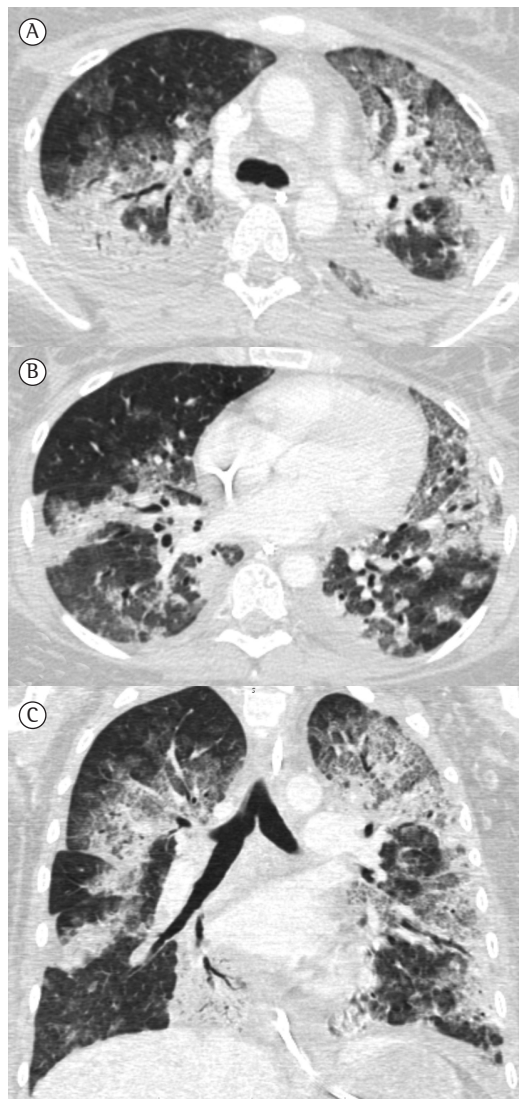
Axial HRCT slices at the levels of the upper lobes (A) and lower lobes (B), as well as reformatted coronal image (C), showing extensive areas of consolidation with air bronchograms in both lungs.
